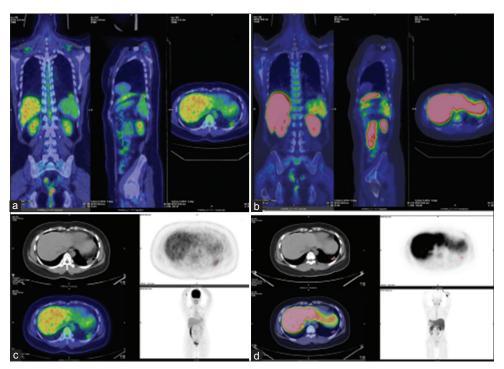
[<sup>18</sup>F]-2'-fluoro-2'-deoxy-D-glucose positron emission tomography/computed tomography images of a 36-year-old patient with choriocarcinoma and lung metastases, acquired 5 months postchemotherapy, revealed a hypermetabolic pulmonary nodule located in the left lower lobe, suggestive of pulmonary metastasis (a and c), which on the [<sup>18</sup>F]-fluorocholine positron emission tomography/computed tomography study showed similar but less uptake intensity (b and d). The surgical bed and regions elsewhere were unremarkable
